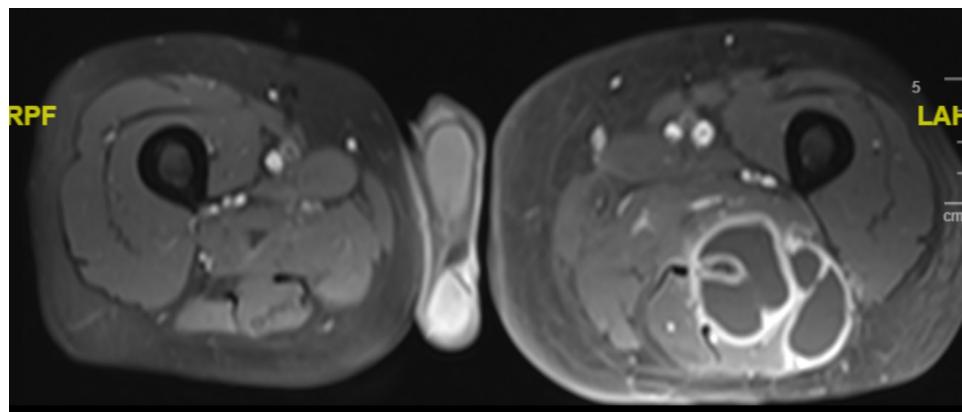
Cystic mass in the left thigh on MRI of the left hip.
